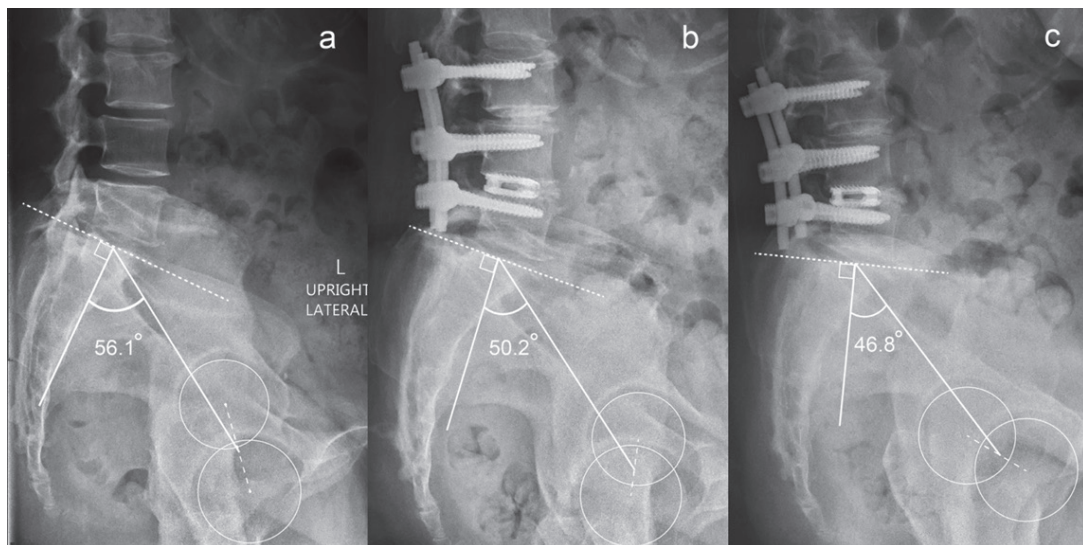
68-year-old female received a L3-5 TLIF surgery for spinal stenosis. Preoperative (a), 6-week postoperative (b) and 1-year postoperative (c) standing lumbosacral lateral radiographs. Note the pelvic incidence (PI) reductions. Preoperative PI was 56.1°, 6-week postoperative PI was 50.2° with Pelvic incidence disparity (Δ PI) as 5.9°. PI at 1-year postoperative follow-up decreased to 46.8° with Δ PI 9.3°.
